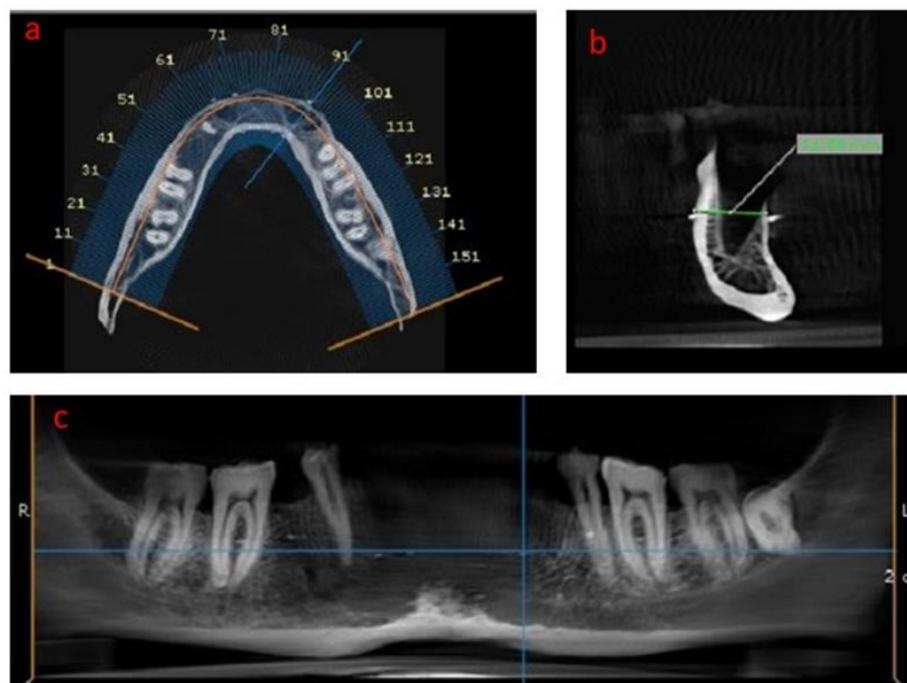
Measurement of bone height in CBCT image in (a) axial, (b) cross-sectional, and (c) panoramic views
